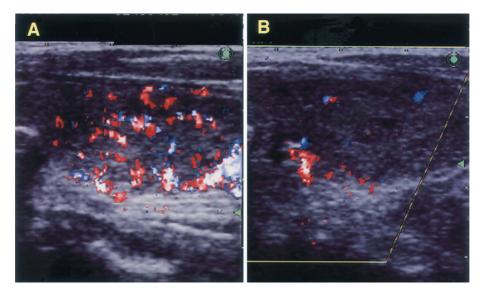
Color Doppler ultrasonography of the thyroid gland. Color Doppler flow ultrasonography revealed an increased blood flow of the thyroid gland in Patient 1 (the left lobe, longitudinal view) when his TSH was elevated (panel A), whereas it showed normal blood flow when he became euthyroid (panel B).
